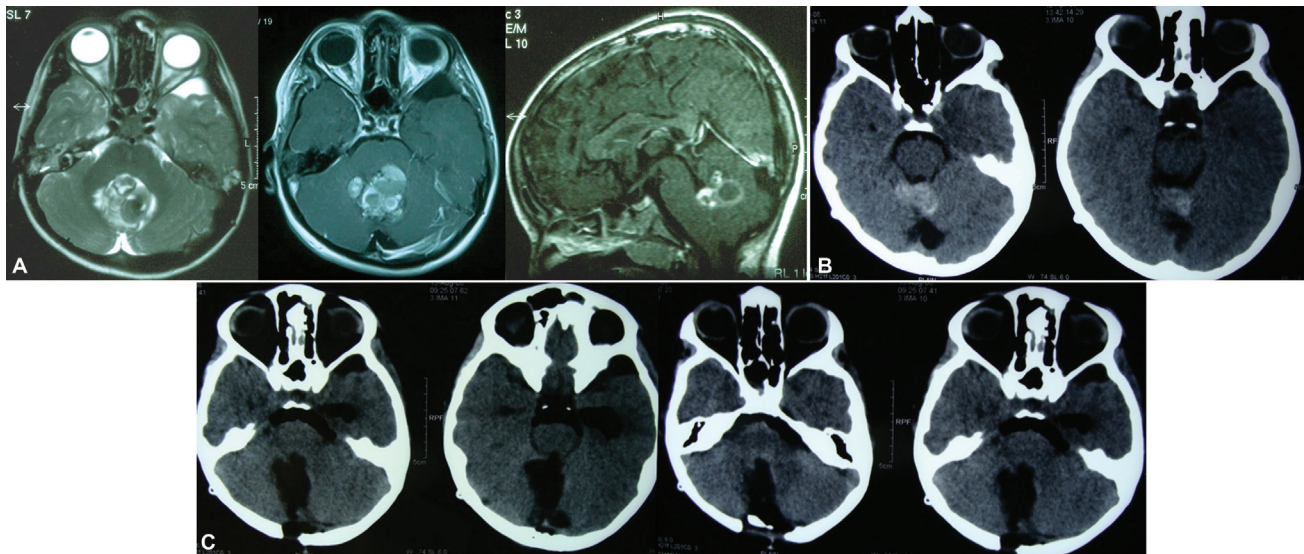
(A) T2-weighted (left) and postcontrast axial (middle) and sagittal (right) images of a 9-year-old boy with a cerebellar vermian multicystic cavernoma with peduncular extension. (B) Six months after surgery, the boy presented in-extremis with a bleed from a small peduncular remnant at the site of the lesion. (C) Postoperative computed tomography scan after second surgery, showing complete excision.
